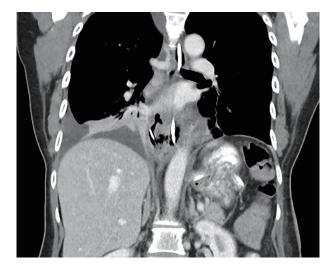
CT image, coronal view, showing double J catheter in esophagus traversing through the defect with distal end in the paraesophageal collection.
